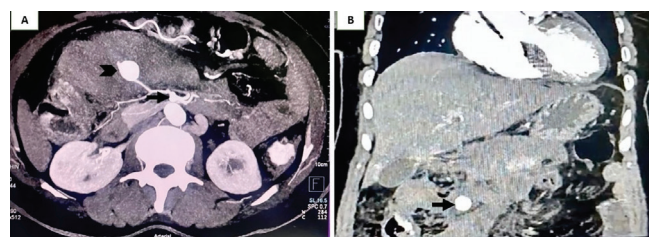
(A) Axial section CT angiography showing a saccular outpouching (arrowhead) from a branch of the superior mesenteric artery (arrow) with a surrounding hematoma. (B) Coronal section showing the pseudoaneurysm (arrow).
